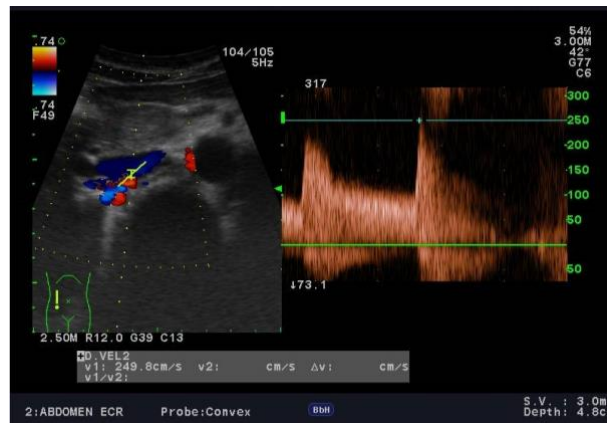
Doppler spectrum at the site of stenosis in the middle segment of the right renal artery in 36-year-old female with fibromuscular dysplasia of renal artery. PSV = 2.5 m/s (a). The same patient, typical finding of FMD of the right renal artery with digital subtraction angiography (b).
